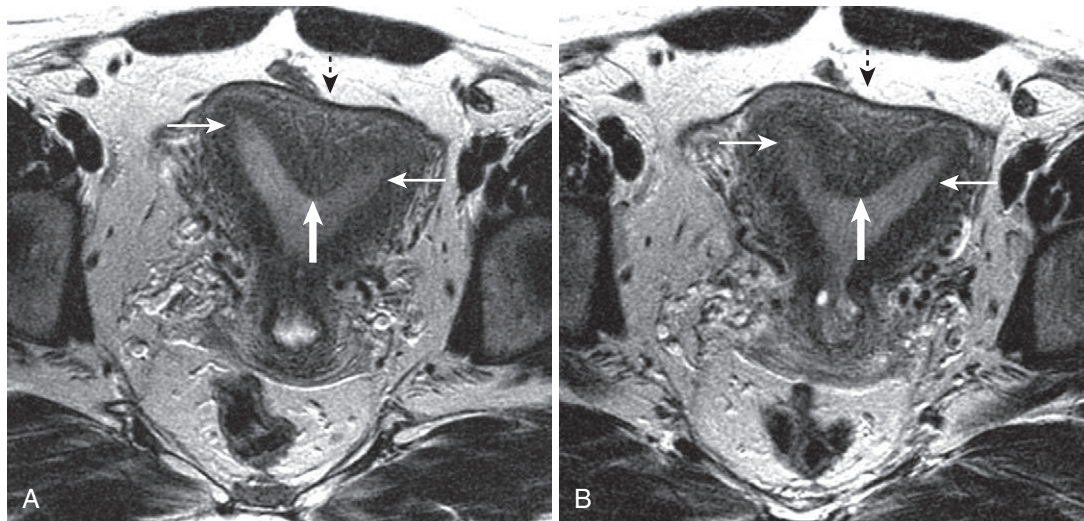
Arcuate uterus. A and B, Myometrial tissue (*thick arrow*) separating relatively closely apposed uterine cornua (*thin arrows*) associated with a convex fundal contour (*broken arrow*) defines the arcuate uterus, as seen on these axial T2-weighted images.
